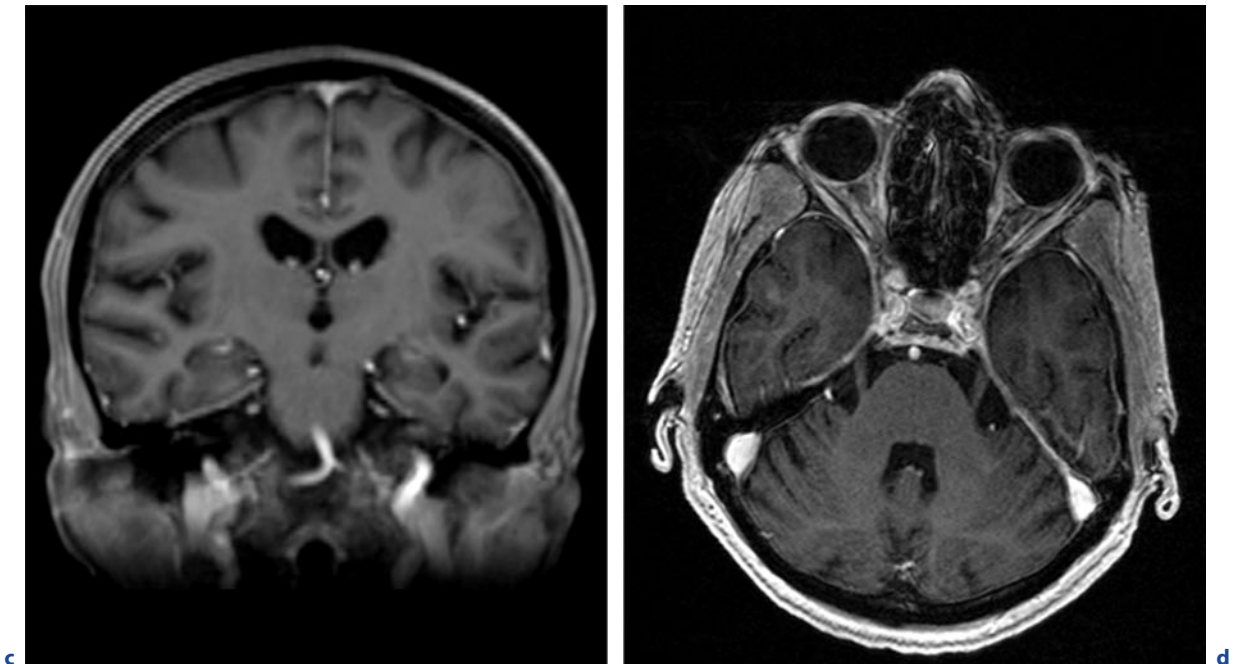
(continued) Neuroborreliosis. Routine follow-up MRI scans of a 67-year-old immunocompromised woman. d Axial T1-weighted images after contrast administration. c Coronal T1-weighted image after contrast administration.
